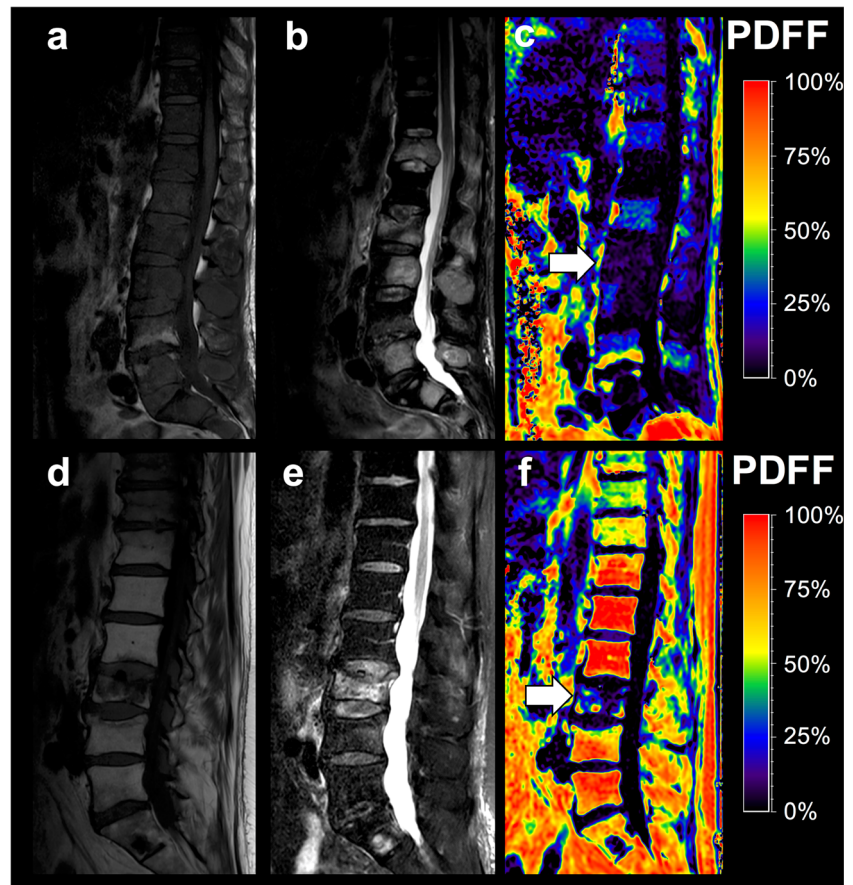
Assessment of proton density fat fraction (PDFFF) derived from six-echo modified Dixon (6E-mDixon) in malignant vertebral compression fractures (VCFs). a-c Image set of a 51-year-old man with osseous metastasis from non-small cell lung cancer and malignant VCF of the L2 vertebral body. Sagittal T1-weighted (a) and T2-SPAIR-weighted (b) images. The corresponding PDFFF map with a coloured PDFFF %-value scale (c) shows an intravertebral PDFFF of 1.8%, which is suggestive of a malignant lesion. d-f Image set of a 63-year-old man with osseous metastasis from prostate cancer and biopsy proven malignant VCF of the L2 vertebral body. T1-weighted (d) and T2-SPAIR-weighted (e) images and the corresponding PDFFF map (f) showing an intravertebral PDFFF of 3.4%, indicating the fracture is malignant
